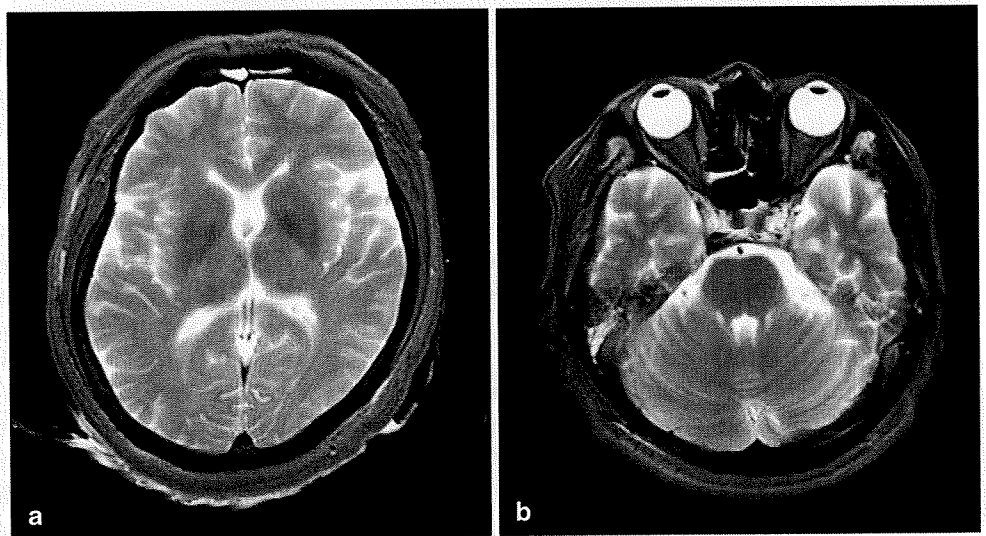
A 37-year-old woman. Postmortem MRI—fluid attenuated inversion recovery (FLAIR) image—of the brain obtained 36 h after confirmation of death shows insufficient signal suppression of the cerebrospinal fluid
